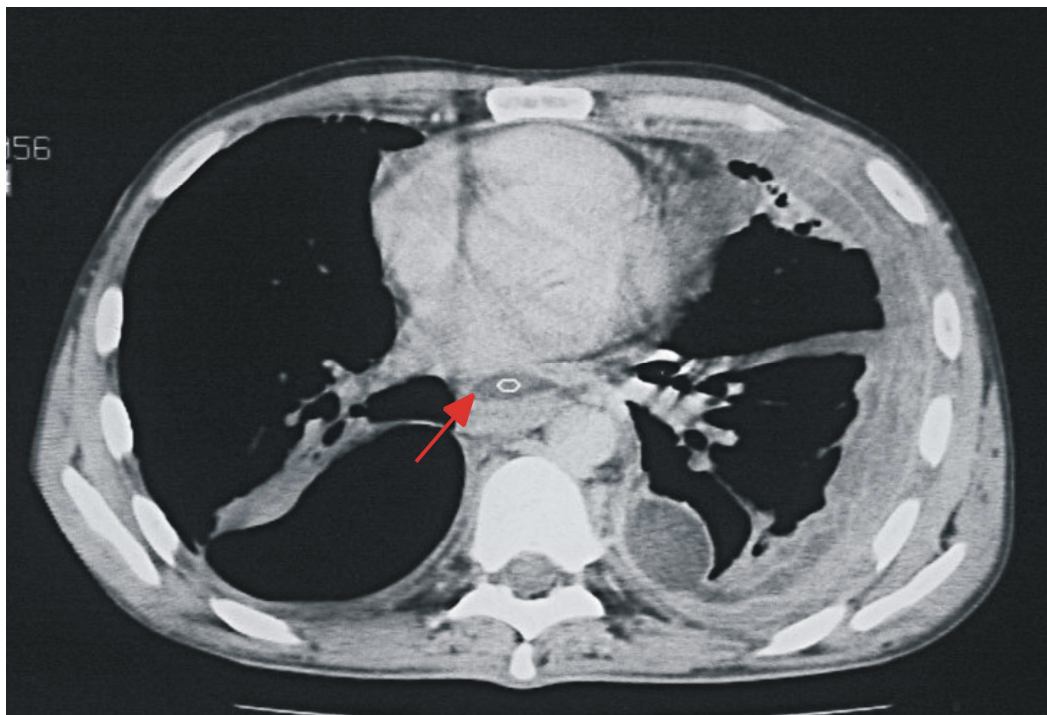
CT bilateral fluidothorax, fistulous tract in the mediastinum.
